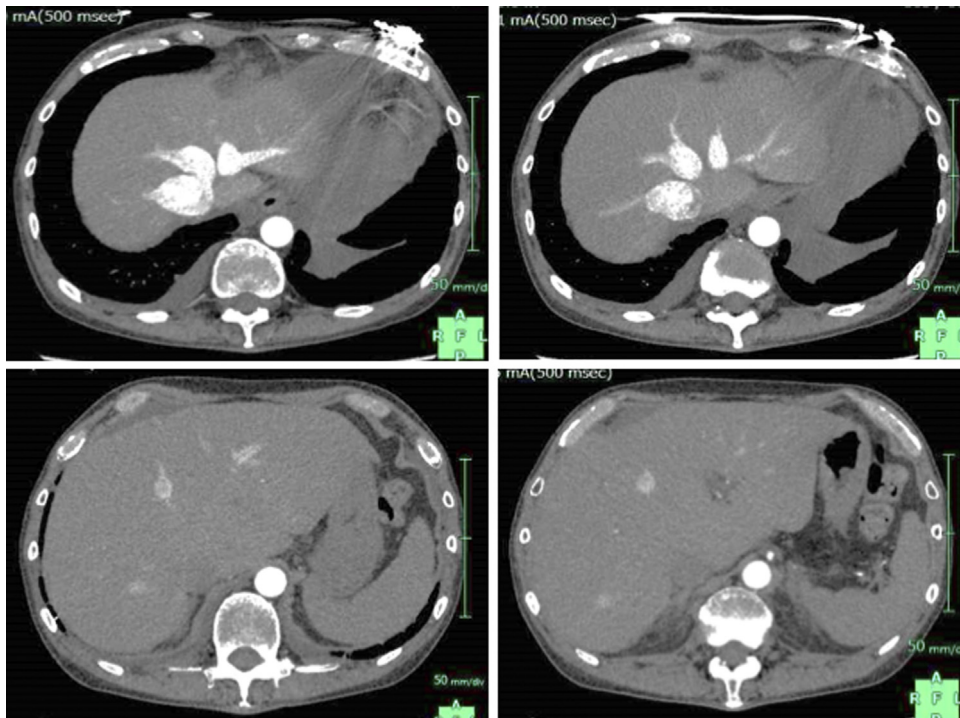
Abdominal CT scan at 8 months prior to the donor surgery. There was no significant liver abnormality except for early enhancement of dilated hepatic veins.
